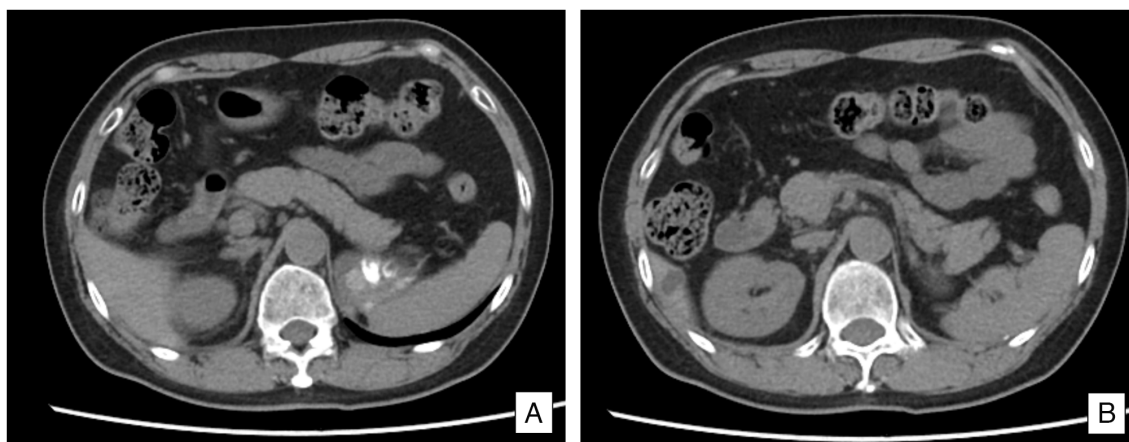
Computed tomography scan of the abdomen. (A) The pancreas is well-defined, with normal size and shape. (B) The surrounding adipose tissue is clearly visible.
